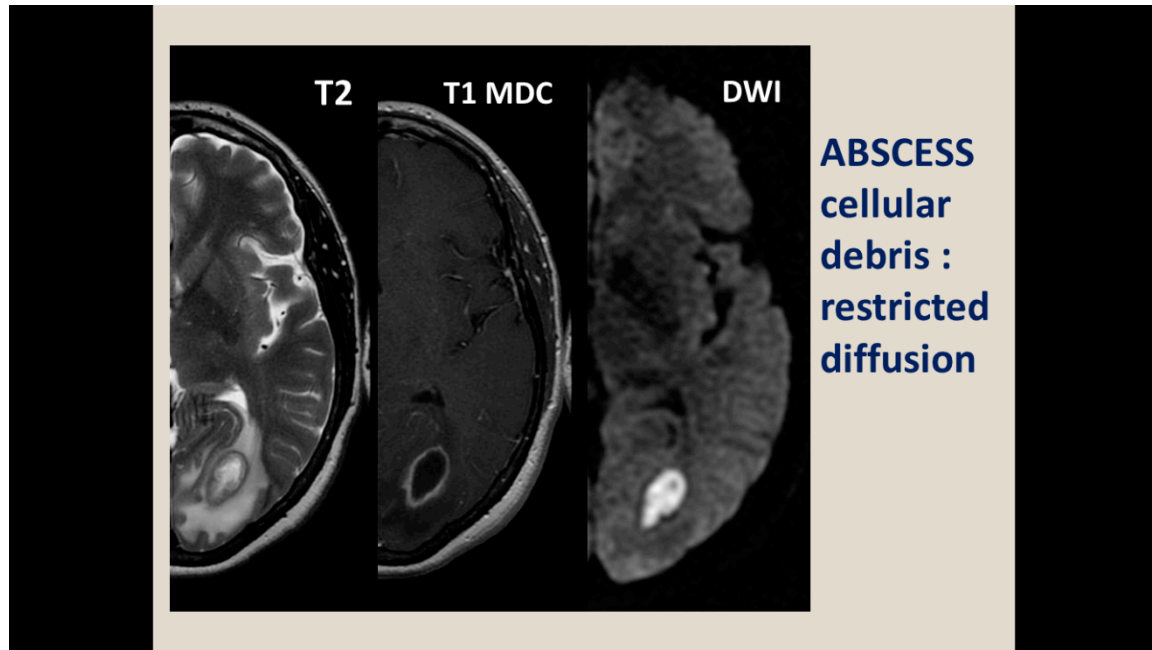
From left to right: small lesion in the left occipital lobe; T2 weighted image shows fluid content in the core of the lesion. After contrast administration (gadolinium) T1-weighted image shows subtle enhancement of its wall. The DWI sequence shows restricted diffusivity of the content of the lesion suggestive of purulent material (pyogenic abscess).
